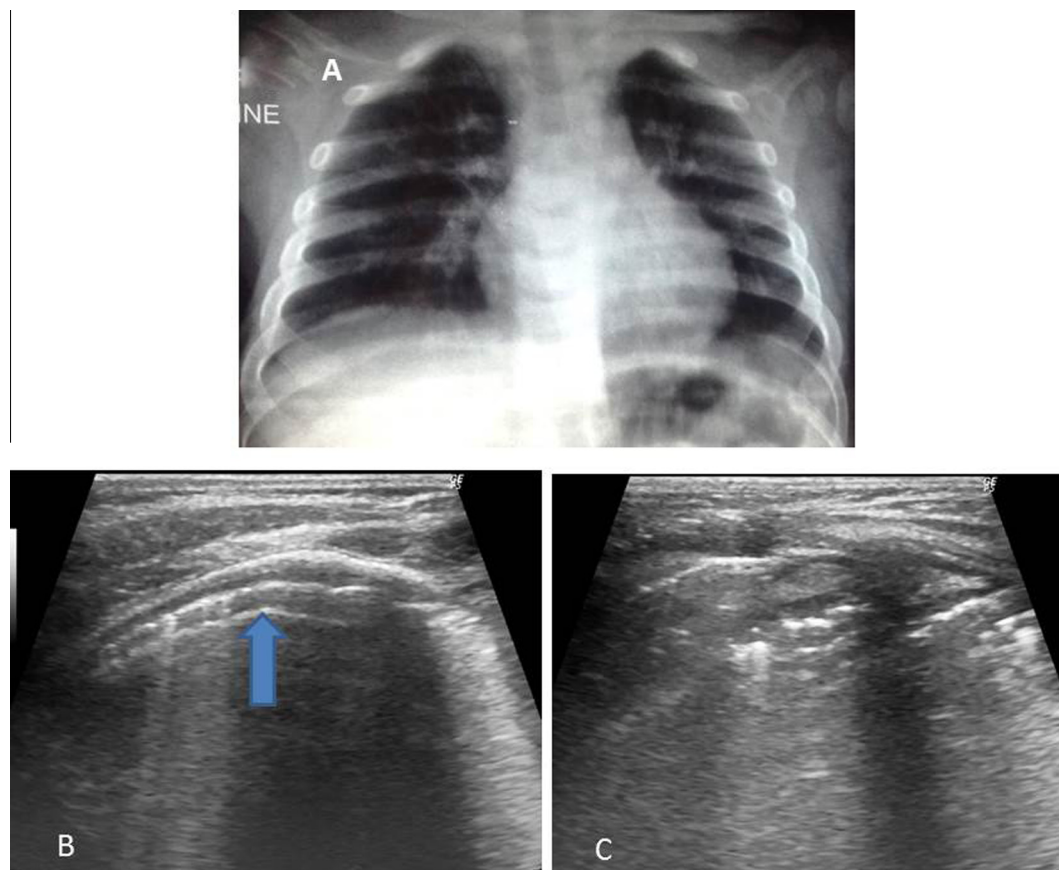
A – Chest X-ray of 3 months-old infant with clinical suspicion of mild bronchiolitis revealed normal X-ray findings. B and C – Lung ultrasound of the same patient showed clearly the pleural line irregularities on Rt. lung (arrow on B). (Patient with normal chest X-ray and abnormal lung ultrasound.)
